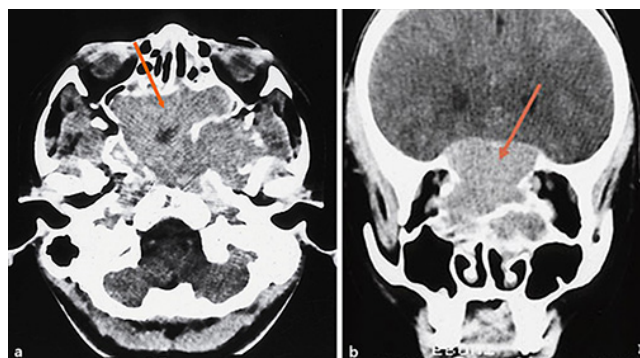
Horizontal (a) and frontal (b) Orbital findings on a female patient who was 13 years old. The condition of the intracranial optic nerves was not known at the time, although CT scan images at that time showed a sizable tumour extending from the sphenoid sinus to the ethmoid sinus. b The optic nerve may be indicated by the orbits and chiasmal region (arrow).
